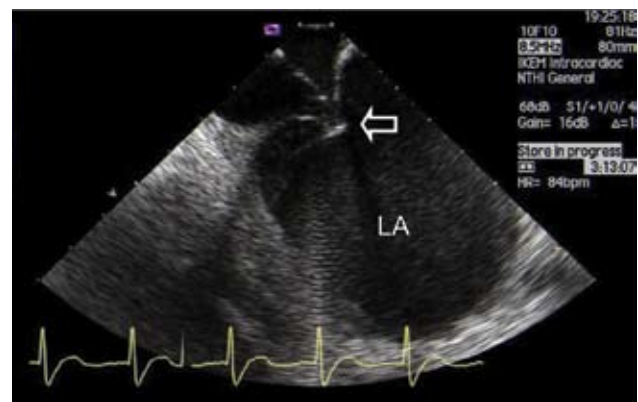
Intracardiac echocardiogram of both atria obtained immediately before transseptal puncture. Note tenting of the interatrial septum by transseptal needle (arrow) from the right atrium towards the left atrium (LA).
